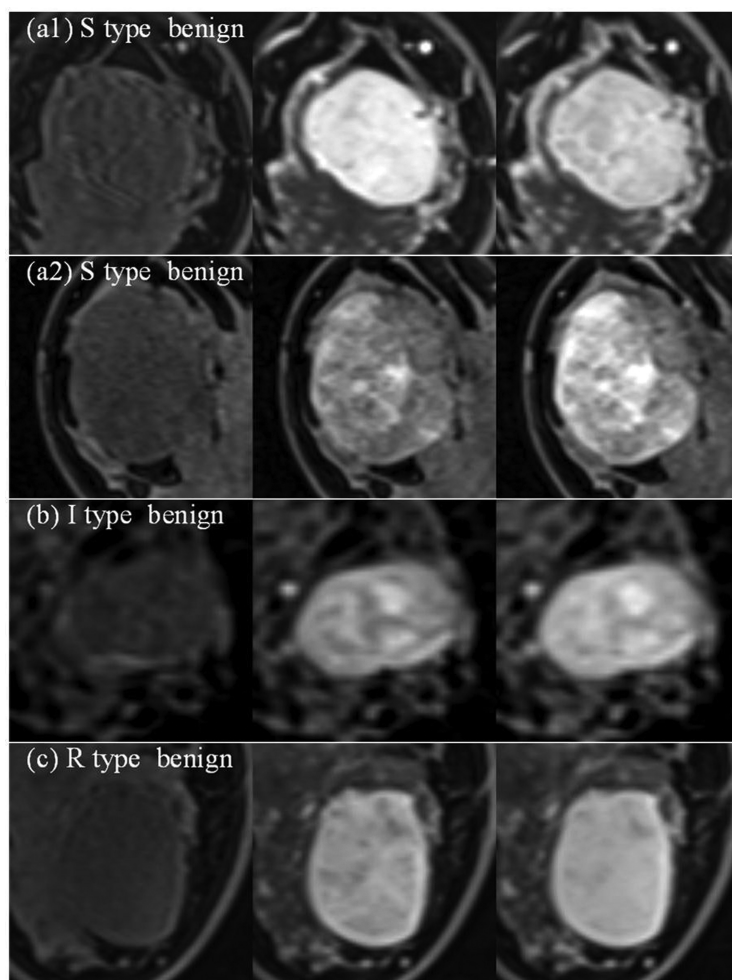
DCE MRI of masses corresponding with benign masses indicated by (a1, a2, b, and c) in Fig. 2 are shown in (a1), (a2), (b), and (c), respectively. Figures at left, center, and right corresponding with pre-contrast phase, initial phase around 2 min after injection, and last phase around 5 min after injection, respectively. I, irregular without Rim-enhancement; R, irregular with Rim-enhancement; S, smooth.
